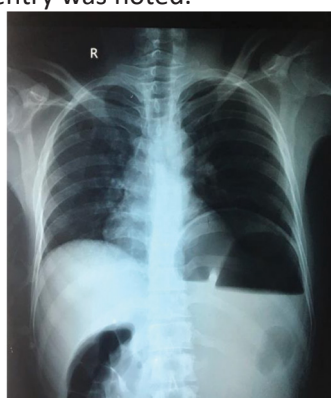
Chest x-ray showing left hemi-diaphragmatic elevation with pneumoperitoneum.
